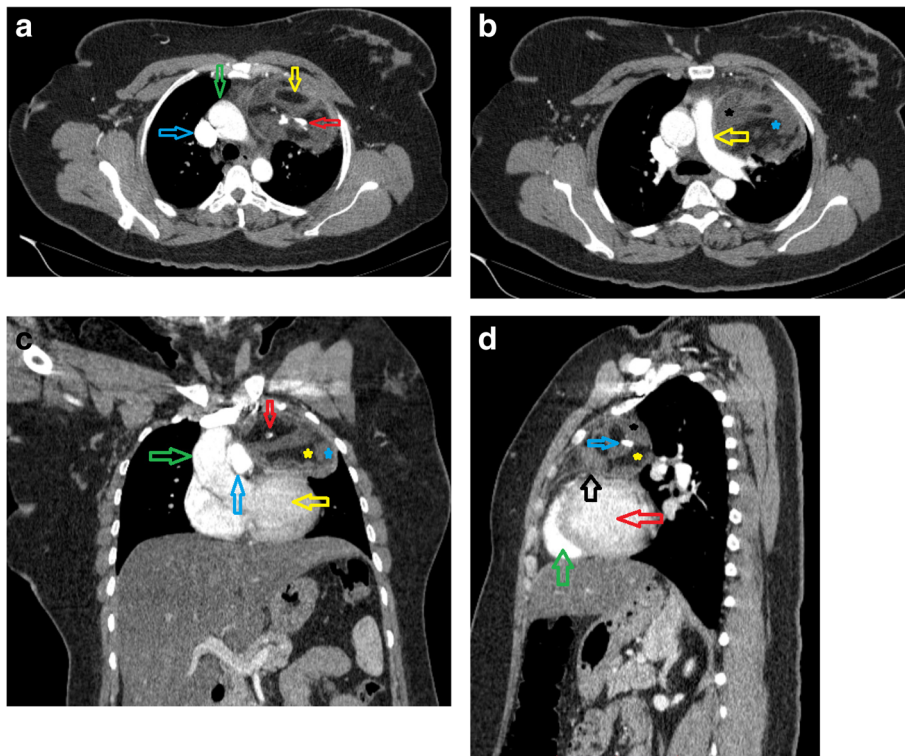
a, b Axial contrast-enhanced CT scan images show teratoma in the left aspect of the anterior mediastinum. a Fat component (yellow arrow), dense calcification (red arrow), aortic arch (green arrow), and superior vena cava (blue arrow). b Soft tissue and cystic fluid components (black asterisk), fat component (blue arrow), and pulmonary trunk and left pulmonary artery (yellow arrow). c Coronal contrast-enhanced CT scan image shows teratoma. Dense calcification (red arrow), fat component (yellow asterisk), soft tissue component (blue asterisk), left ventricle (yellow arrow), ascending aorta (green arrow), and left pulmonary artery (blue arrow). d Sagittal contrast-enhanced CT scan image shows teratoma in the anterior aspect of the left mediastinum. Fat component (yellow asterisk), dense calcification (blue arrow), soft tissue component (black asterisk), intact pericardium (black arrow), left ventricle (red arrow), and right ventricle (green arrow)
